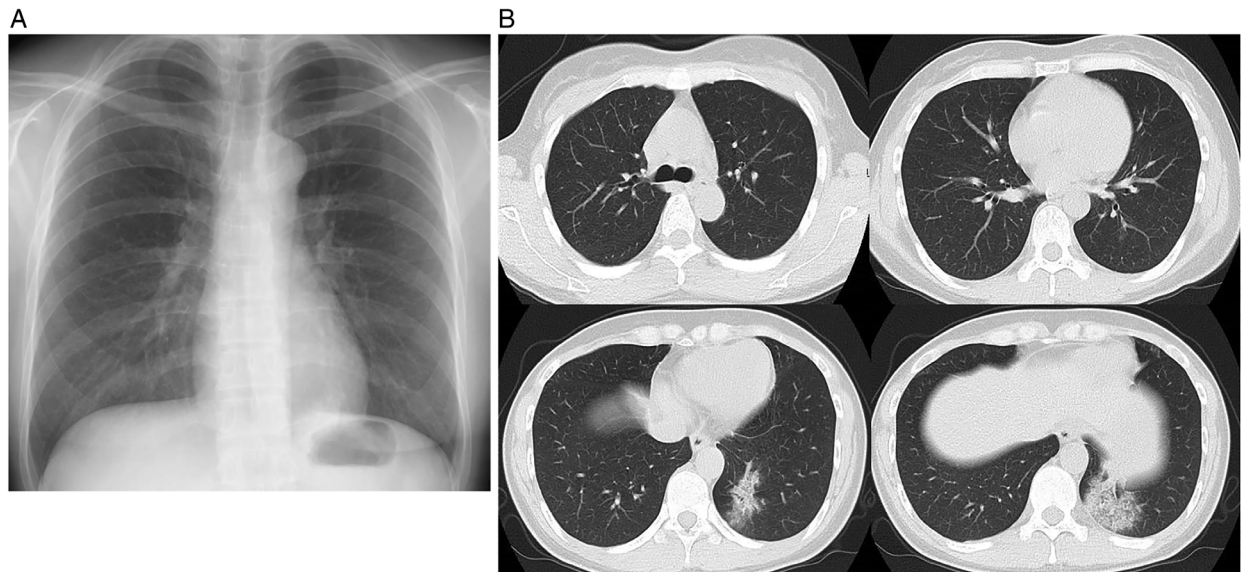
Imaging findings on admission. (A) Chest x-ray shows an opacity infiltrating the left lower lung field. (B) Chest computed tomography shows ground-glass opacity in the left lower lung field
